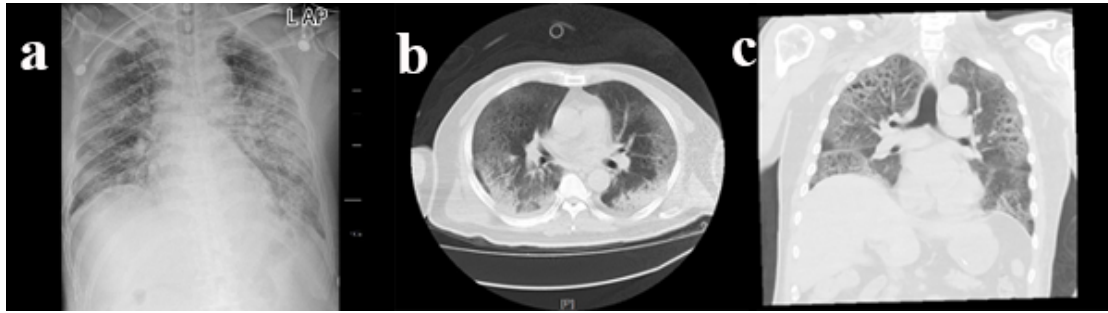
a: bedside chest radiograph on first day of admission; b and c: computerized tomography on the 9<sup>th</sup> day showed typical ground-glass changes of viral pneumonia.
